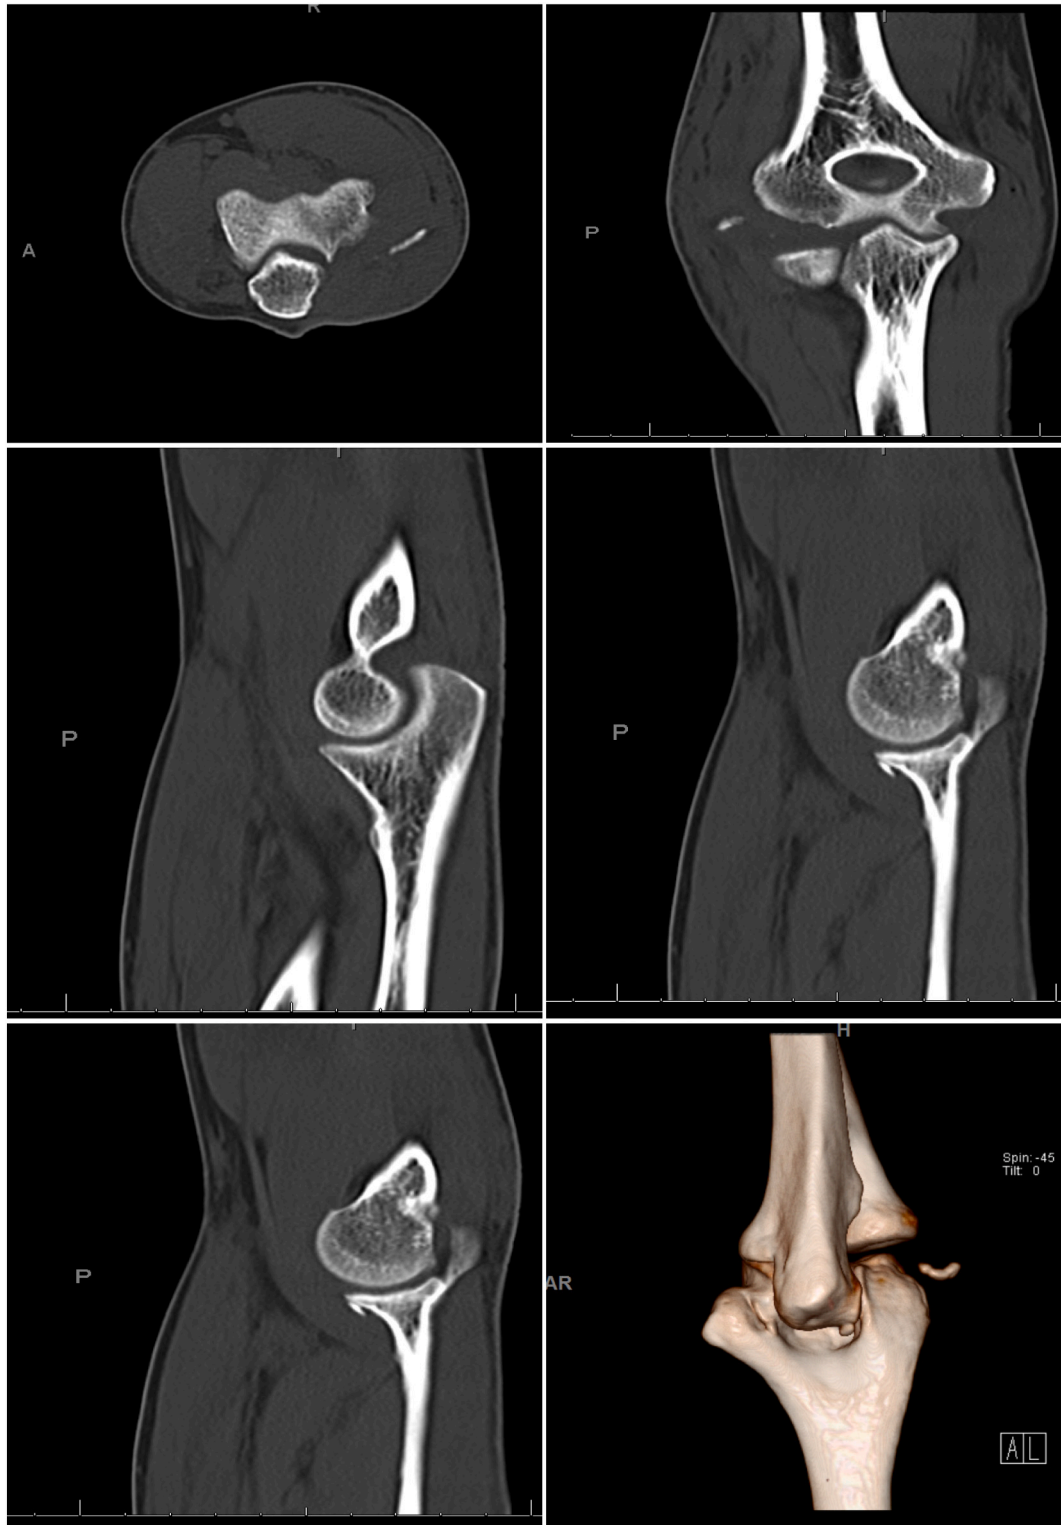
Preoperative computed tomography scanning.
